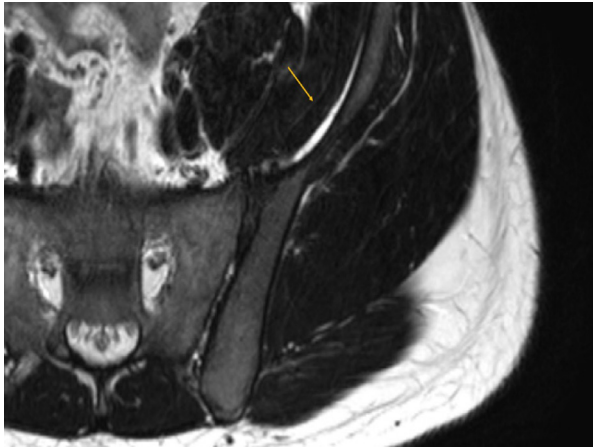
Axial T2-weighted MRI 6 weeks postpresentation showing near total resolution of the lesion.
